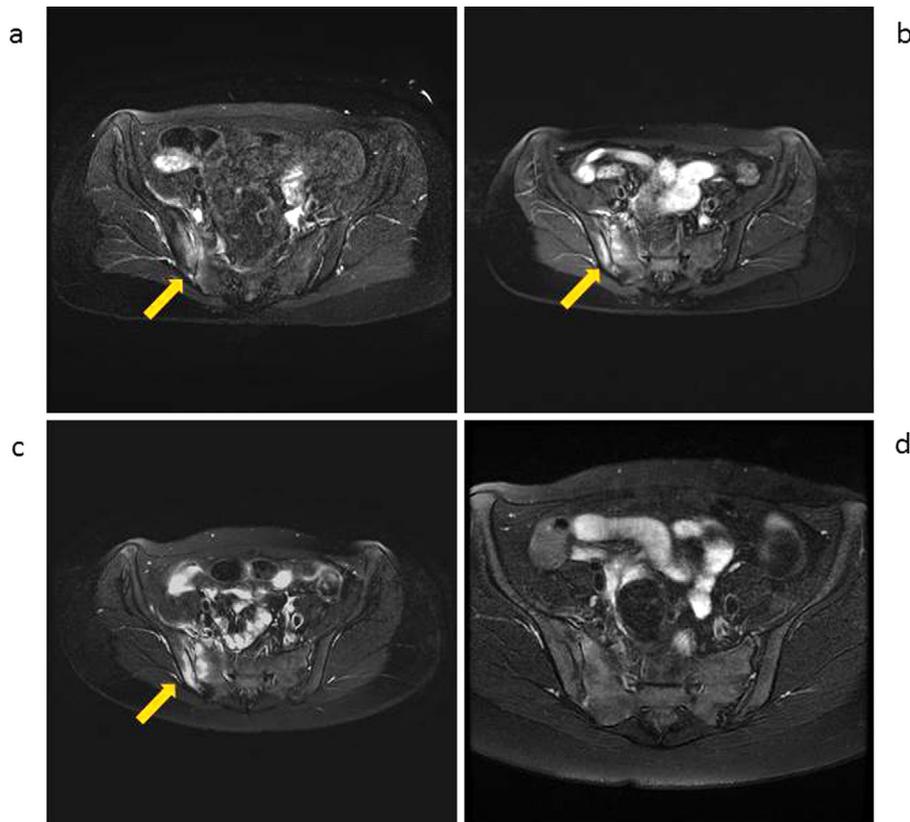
Sacroiliac MRI findings. a: MRI of the pelvis revealed a high-intensity area in the right sacroiliac joint, compatible with the findings of sacroiliitis due to MRSA infection. b: MRI of the pelvis performed after four weeks of treatment with LZD. c: MRI of the pelvis after an additional four weeks of treatment (eight weeks in total) with LZD. d: MRI of the pelvis performed after a total of 14 weeks of LZD treatment.
